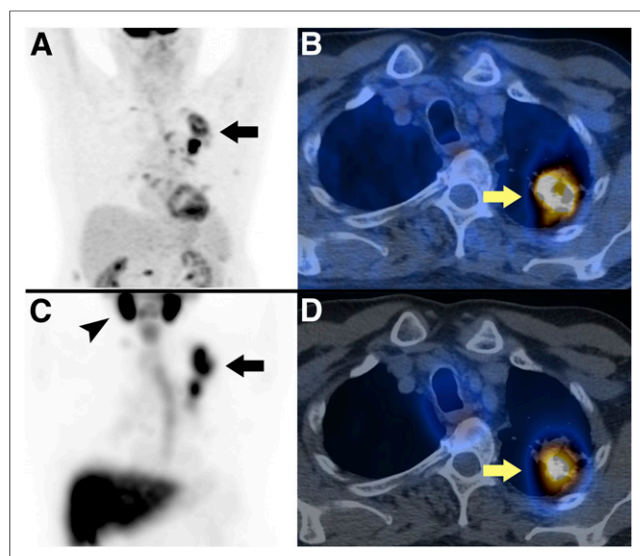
Results from a 61-y-old man with known bronchial carcinoma in left upper lobe. Shown are maximum-intensity-projection PET image (A) and axial fused PET/CT image (B) 42 min after injection of 348 MBq of ^{18}F -FDG and maximum-intensity-projection SPECT image (C) and axial fused SPECT/CT image (D) 4 h after injection of 587 MBq of $^{99\text{m}}\text{Tc}$ -PAMA-cobalamin. On maximum-intensity-projection image in A (^{18}F -FDG) and C ($^{99\text{m}}\text{Tc}$ -PAMA-cobalamin), tumor is highly active on both images (arrows). In addition, C shows high tracer accumulation of $^{99\text{m}}\text{Tc}$ -PAMA-cobalamin in salivary glands (arrowhead) and liver. Mean relative tracer accumulation in different organs in relation to whole-body scan were liver, 28%; left kidney, 1%; lungs, 7%; and tumor, 3%.
